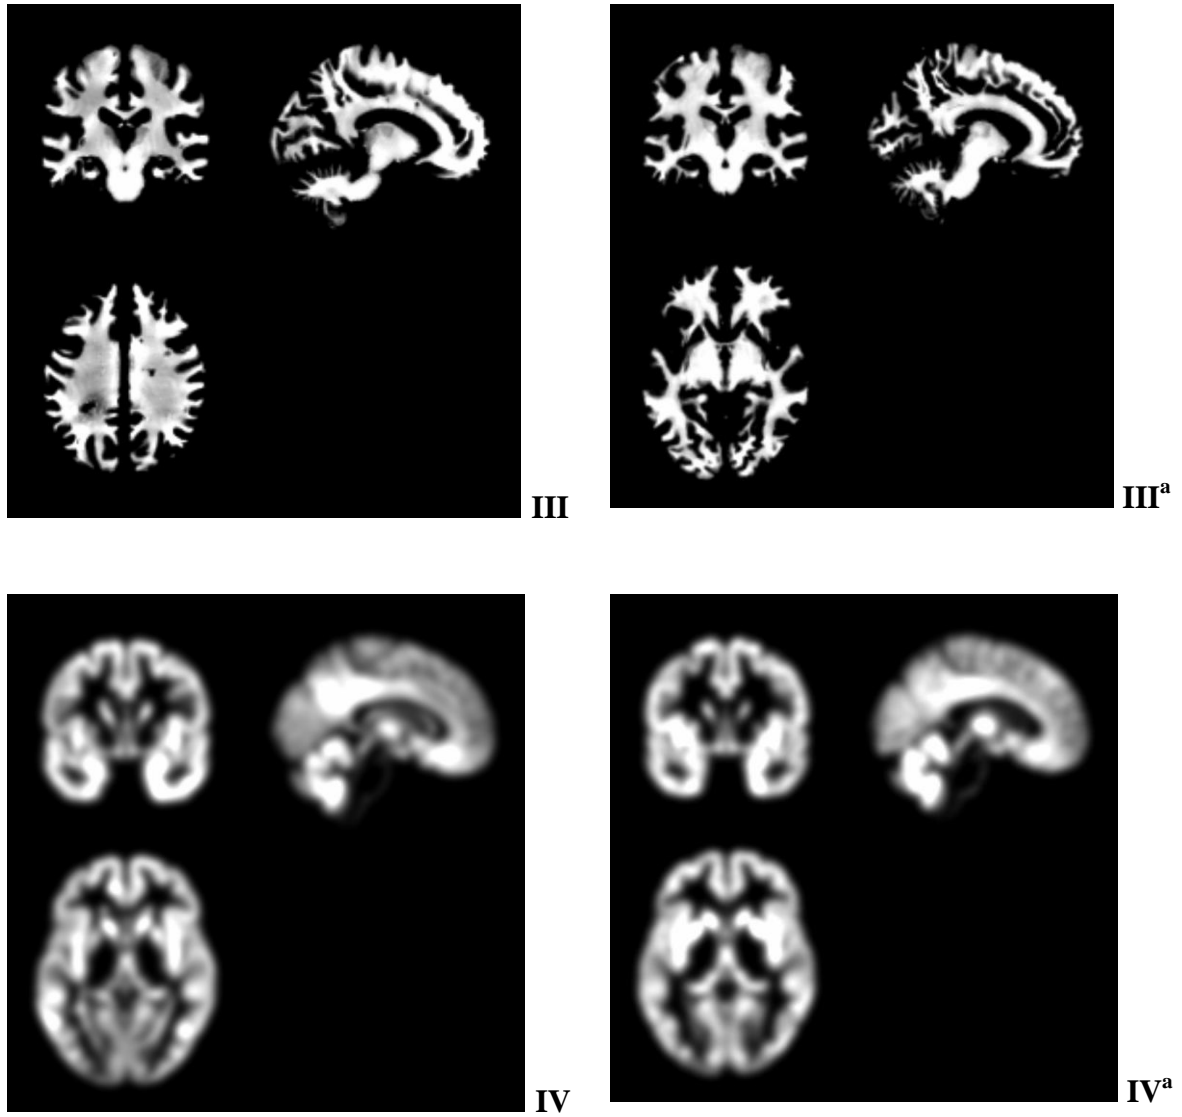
Comparison MRI assessment of MS patient (left) and normal control (right)^a I- T1 average acquisition II-Segmented grey matter analysis III- Segmented white matter analysis IV- Smoothed masked (pre-processing for VBM).
